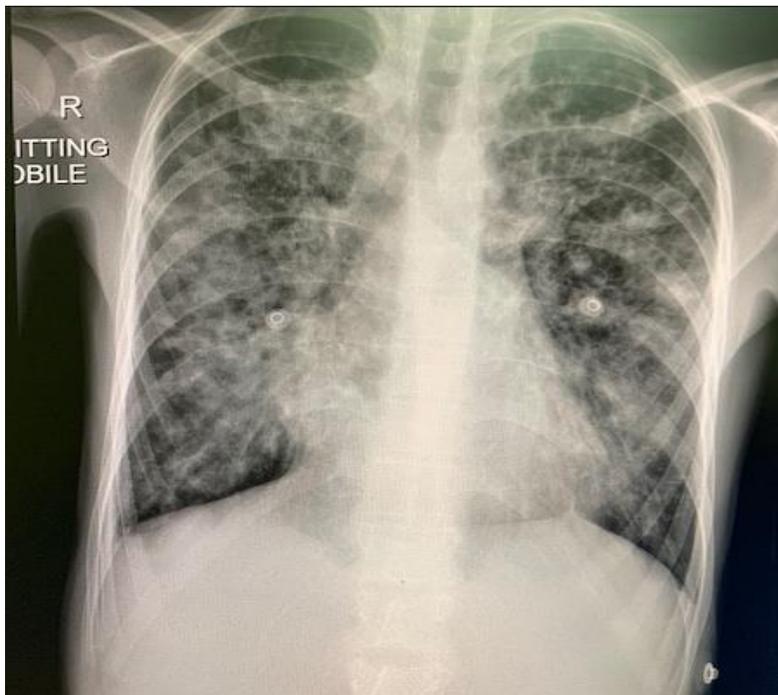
Chest X-ray on admission showing bilateral infiltrates involving more than 50% of the lung zones.
